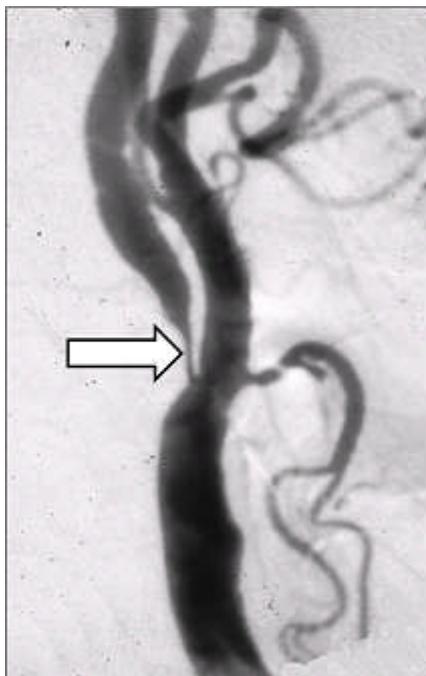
Xray picture after injection of dye into the carotid artery showing severe carotid artery narrowing in the left hand figure (arrow). The right hand figure shows the appearances after the insertion of a metallic stent across the narrowing.
